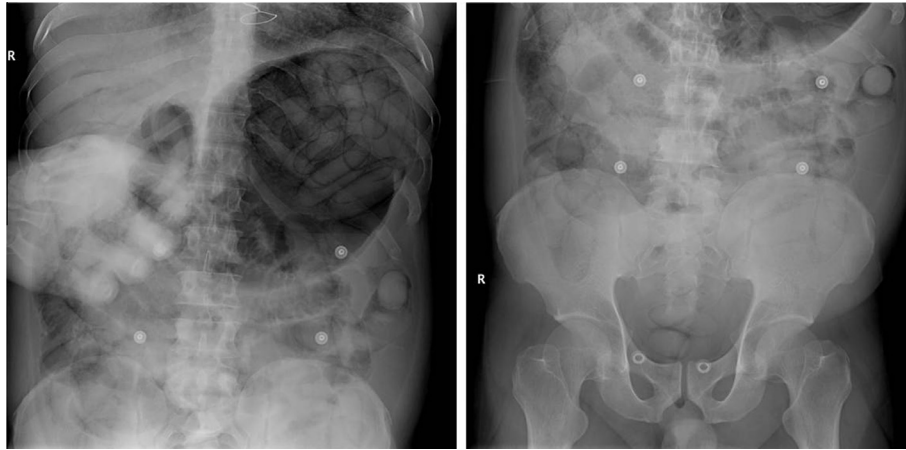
Postmortem radiography showing multiple packages with a surrounding thin rim of halo, producing the “double condom sign”. The halo is produced by the air trapped between the dense packet content and the outermost wrapping layer.
